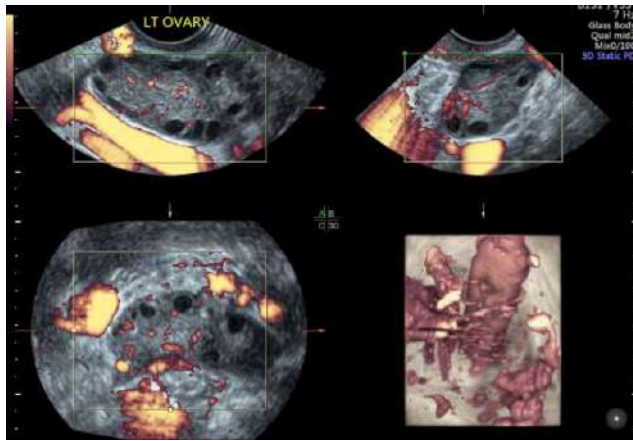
3D power Doppler volume acquired by 3D ultrasound.
